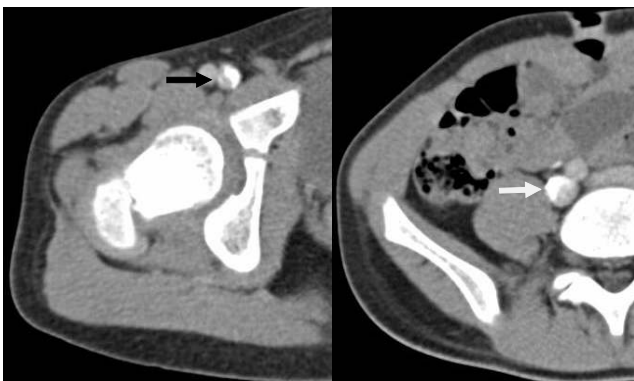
Computed tomographic venography showed a segmental thrombotic filling defect from the right iliac vein (arrow) to the right common femoral vein (white arrow).
